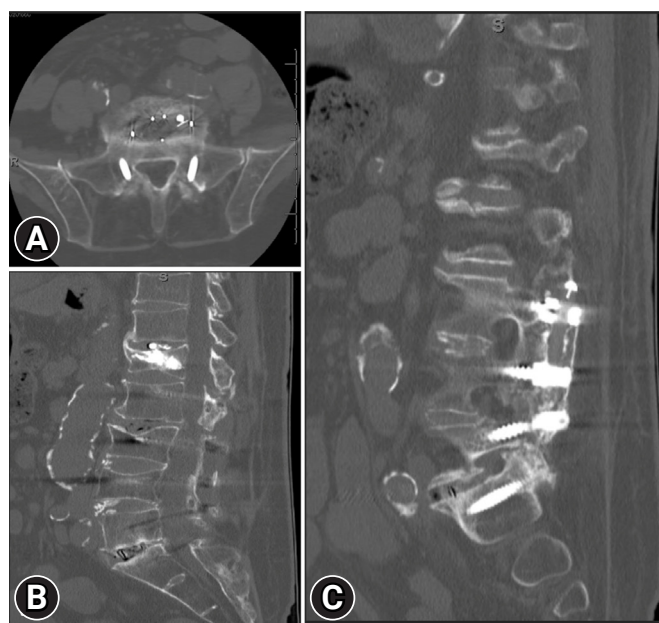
Ten-week postoperative computed tomography scans showing S1 pedicle screw placement in the axial (A) and sagittal views (B), as well as signs (C) of early bony fusion across the facet joint.
